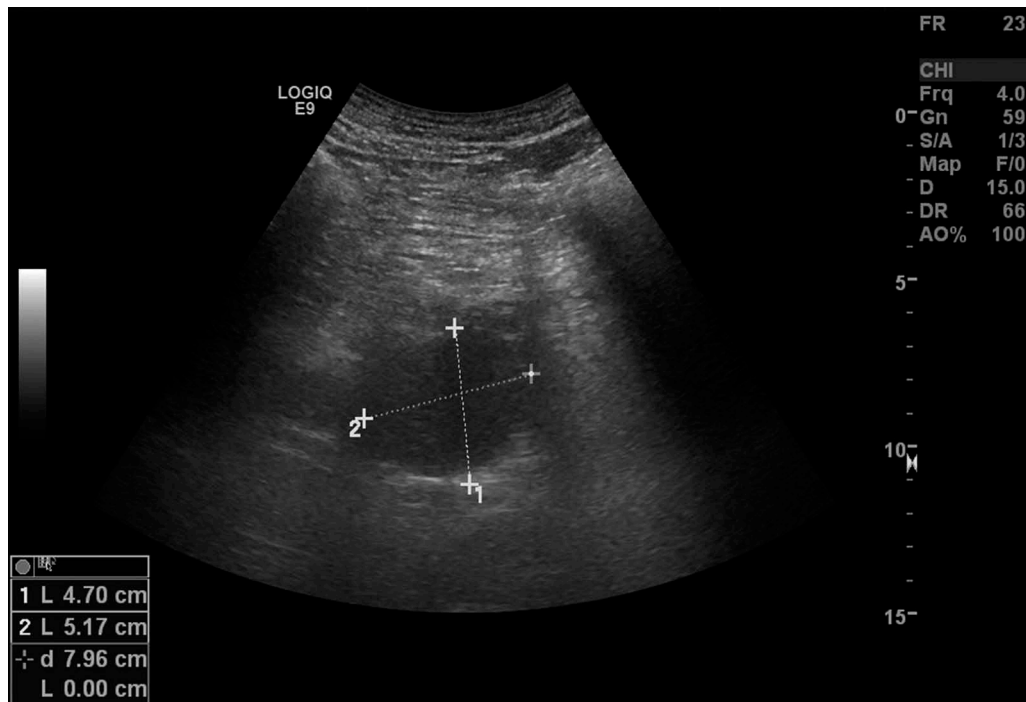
Transverse ultrasound image shows a hypo-echoic mass in the pancreatic region.
